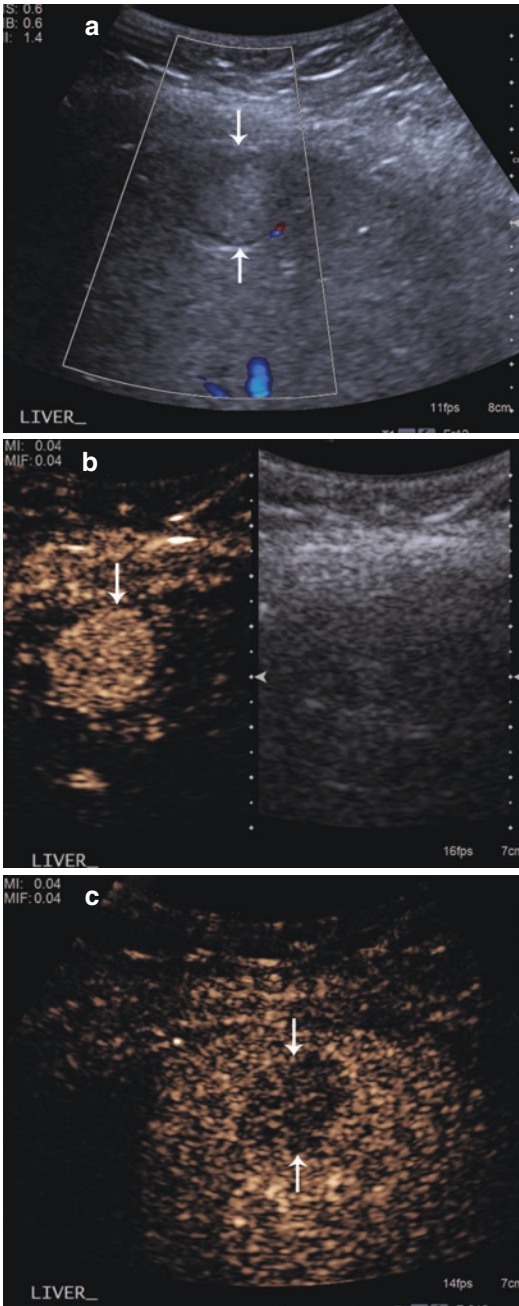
An 11-year-old girl with metastatic pancreatic neuroendocrine tumor. (a) Transverse grayscale ultrasound image shows a slightly hyperechoic subcapsular lesion with a hypoechoic halo and no visible internal vascularity (arrows). (b) Transverse CEUS image (left side of panel) obtained in the arterial phase shows the lesion to be hyperenhancing. (c) This CEUS image obtained in the portal venous phase shows frank washout of the lesion (arrows). These features are consistent with a liver metastasis
